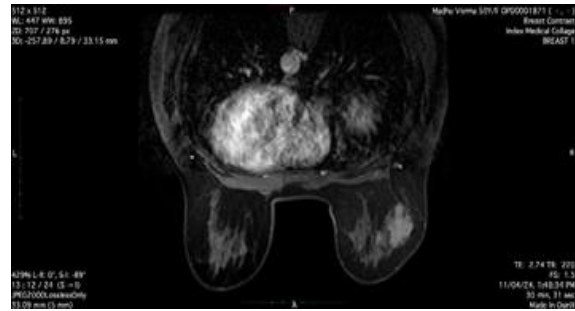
MRI showed ill defined, spiculated lesion in upper outer quadrant of right breast appearing hyperintense on T2/PD FATSAT and hypointense on T1 causing retraction of nipple and shows intense post contrast enhancement s/o carcinoma right breast (BIRADS IV)
